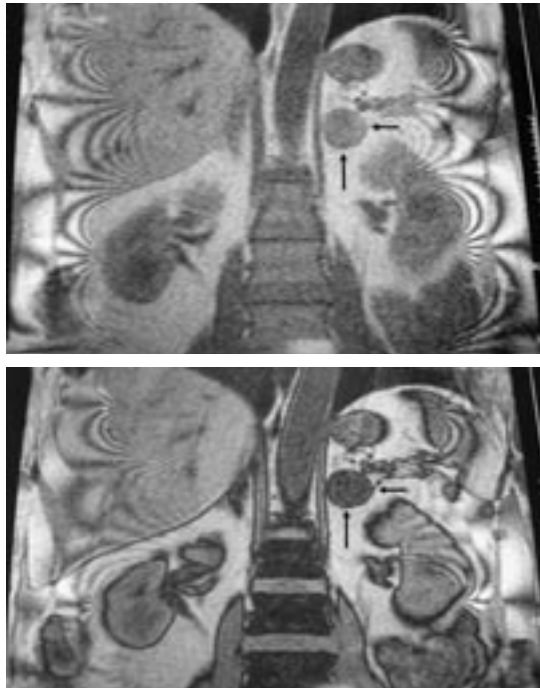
In-phase (top) and out-of-phase (bottom) coronal MRI images in a patient with a left adrenal mass. The reduced signal intensity is due to high lipid content and is consistent with adenoma or hyperplasia.
